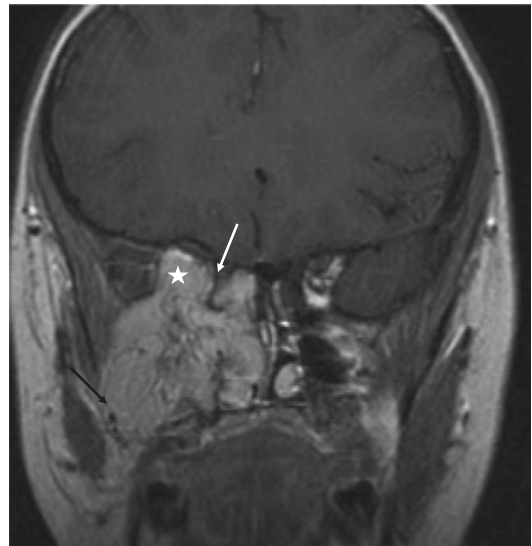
MRI of an extended juvenile angiofibroma. Note the well limited finger-like extensions with isolated voids. *Infratemporal extension; white arrow: cavernous sinus “compressed” between the lateral and medial (sphenoid sinus) tumor extension; black arrow: displaced internal maxillary artery lateral to the tumor extension that fully occupies the right maxillary sinus. The right nasal fossa is blocked by the JA
